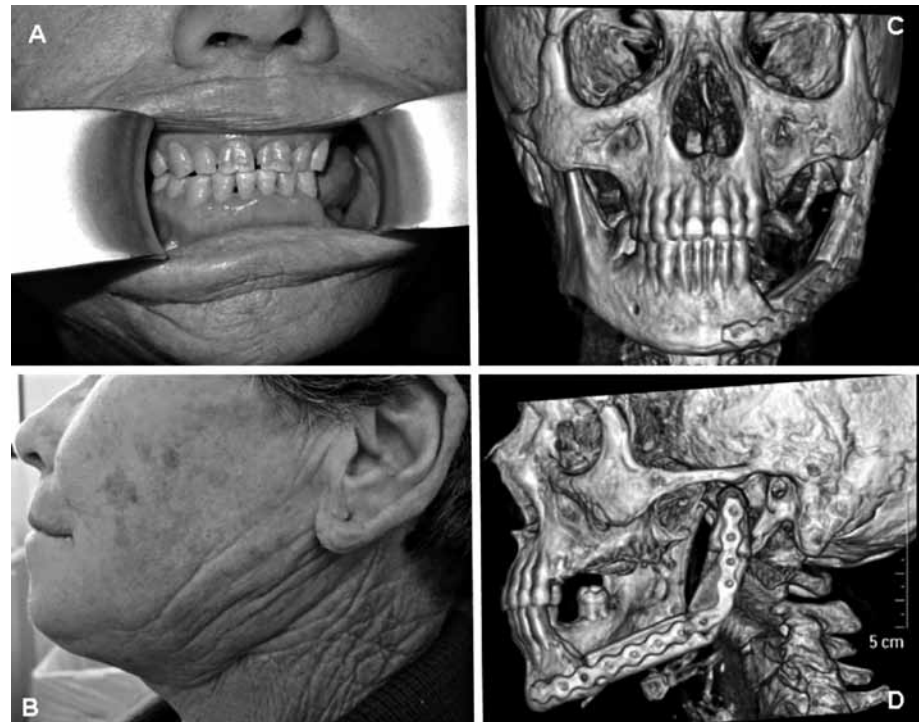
a-b) Frontal and lateral view of the patient after surgery. c-d) 3D-CT 6 months days after surgery.
